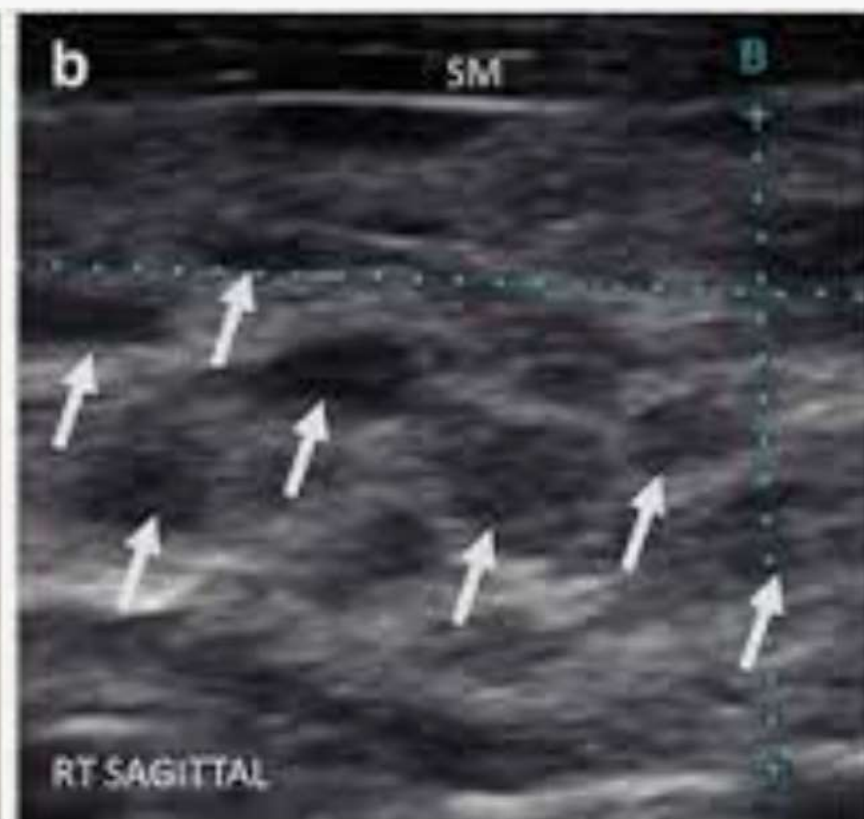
The sonographic appearance of Hashimoto thyroiditis
